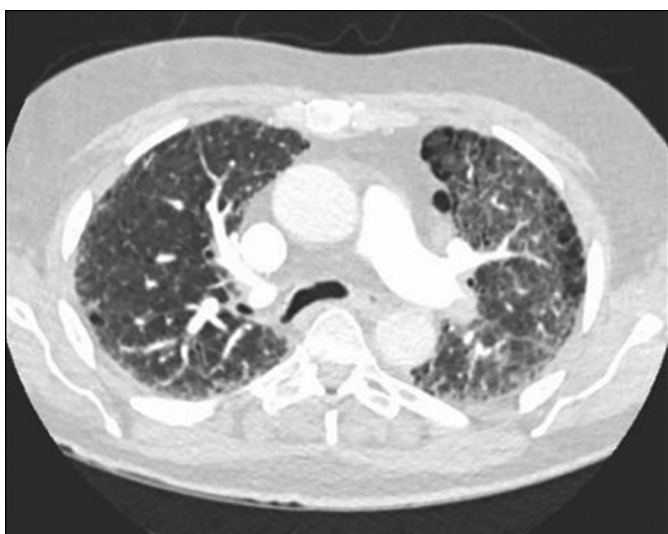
Repeat chest computed tomography 6 months after initial diagnosis and initiation of steroids showing worsened bilateral interstitial fibrosis.
